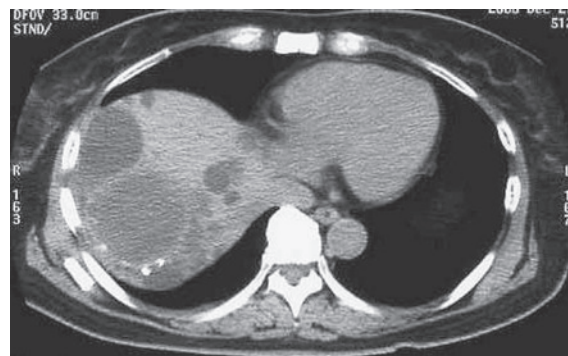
A computed tomographic (CT) scan showing an area of homogenous density (diameter, 6 cm) which was slightly greater than that of the other hepatic cysts in segment 8. There was calcification of the cyst wall.
